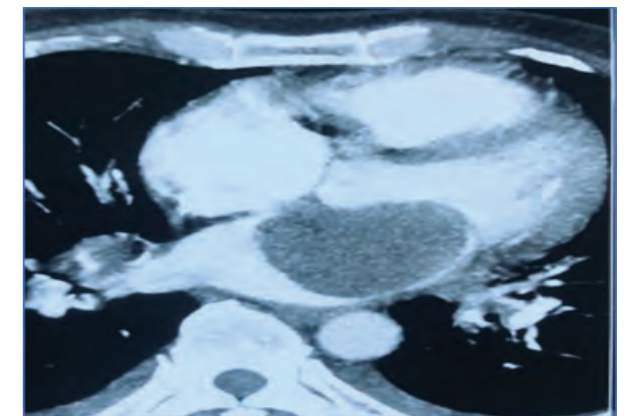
Cardiac CT angio showing LA myxoma
